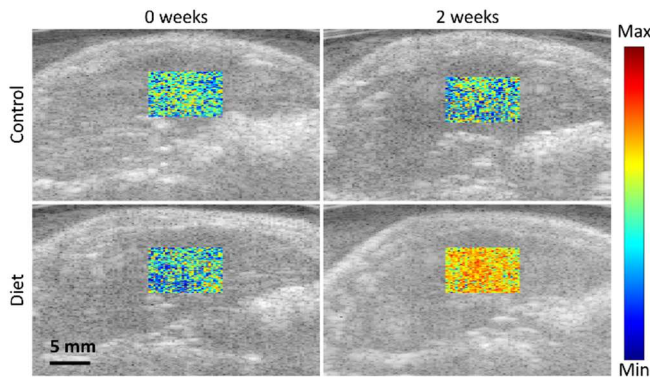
Representative mpUS map overlaid on the B-scan ultrasound (US) images for anatomical guidance. A weighted combination of six different US parameters contributes to the local mpUS image intensity.
